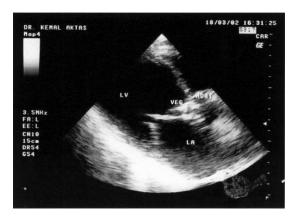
Echocardiographic view of a big vegetation located in the noncoronary cusp of aortic valve of a patient who had severe aortic regurgitation.
